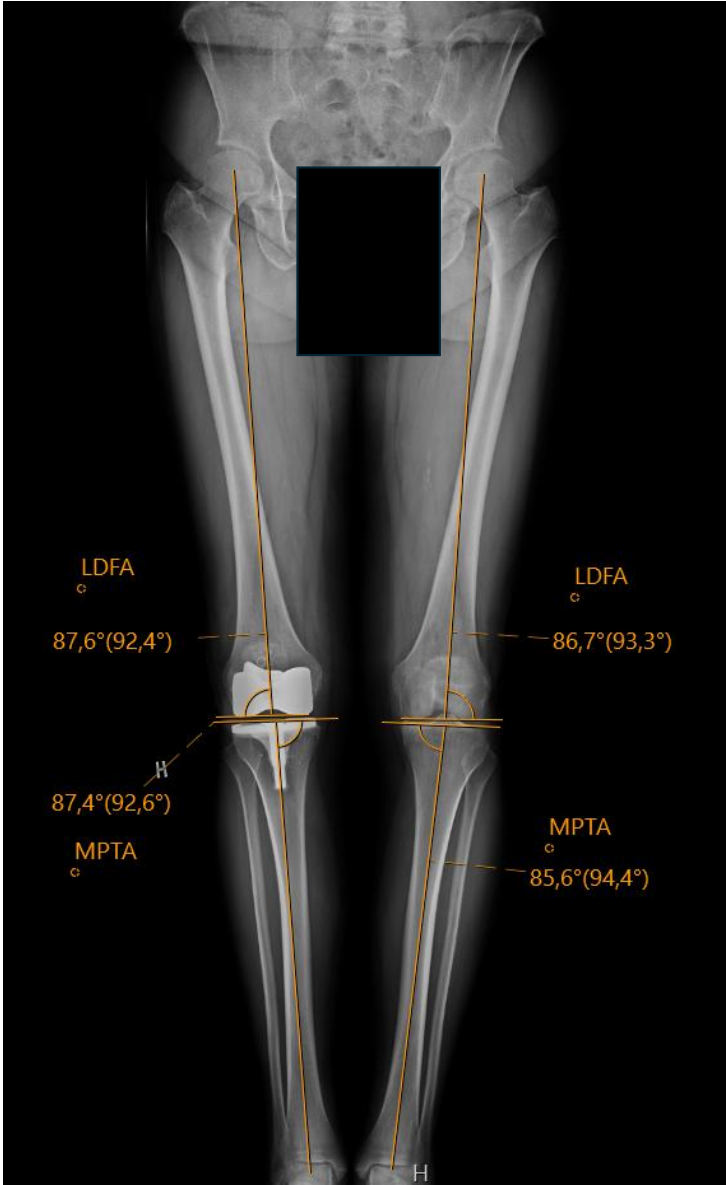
Hip-Knee- Ankle (HKA) radiographs with measurements for calculating constitutional arithmetic HKA and joint line obliquity angle.
